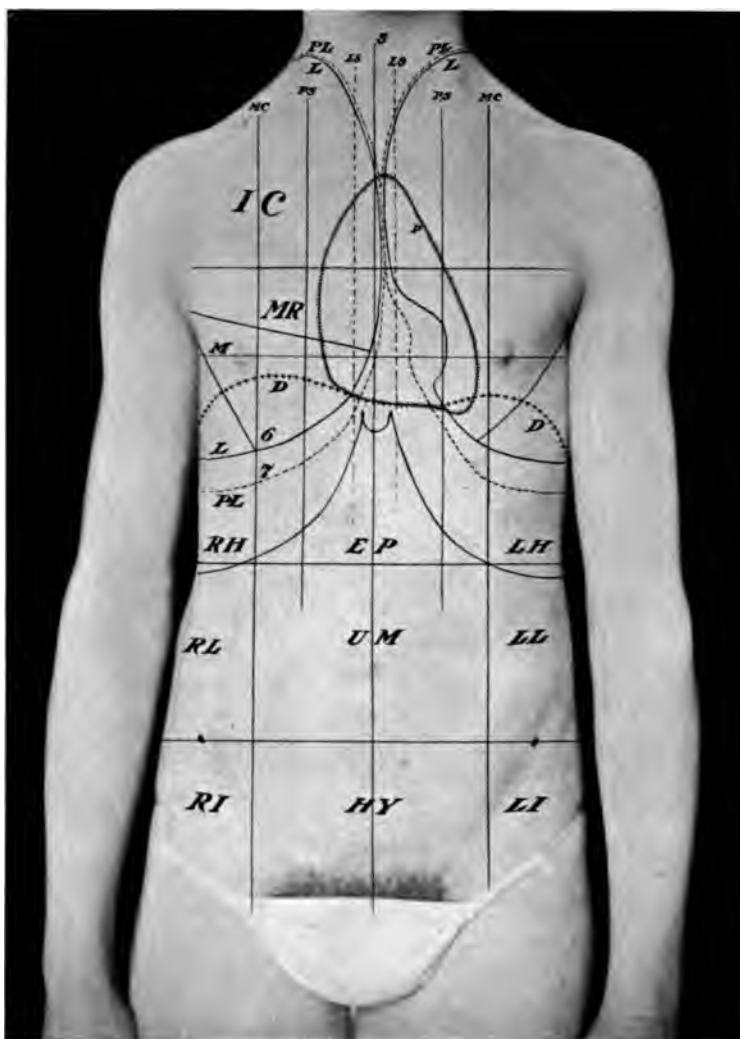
Surface markings of pleuræ, lungs, pericardium, and fissures of lungs; also divisions of abdomen. S, Sternal line. LS, Lateral sternal line. PS, Parasternal line. MC, Midclavicular line. IC, Infraclavicular region. MR, Mammary region. M, Transverse mammary line. PL, Pleura, crossing midclavicular line at seventh rib. Its relation to the pericardium should be noted. L, Surface outline of lungs following closely that of pleura. It crosses the sixth rib at the midclavicular line. P, Pericardium outlined. Its relation to the pleura should be followed. D, Diaphragm. The interlobar fissures are seen upon the right and left sides, showing that upon the right side the right upper, middle, and lower lobes come to the surface of the chest; upon the left side the left upper and lower. RH, Right hypochondriac region. EP, Epigastric region. LH, Left hypochondriac region. RL, Right lumbar region. UM, Umbilical region. LL, Left lumbar region. RI, Right iliac region. HY, Hypogastric region. LI, Left iliac region.
